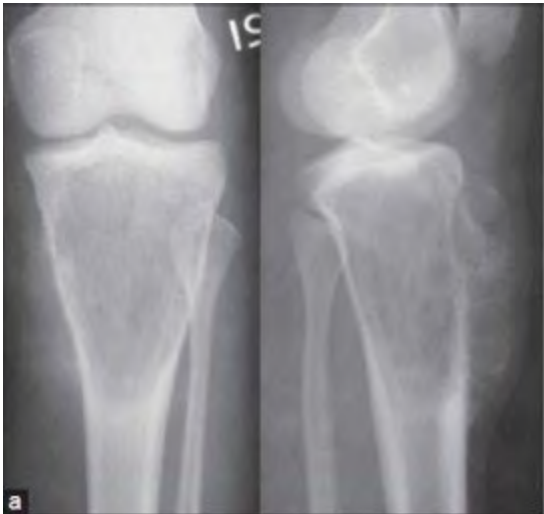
X-ray of Osteosarcoma
